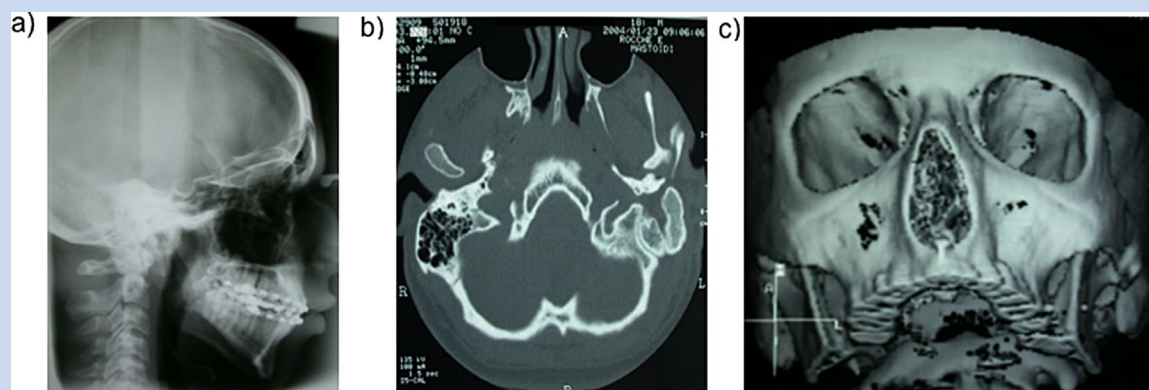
Radiography and CT scan images of the patient with OAVS features and the 3q29 microduplication. [a] Lateral cervical spine radiograph showing no alteration of cervical vertebrae; [b] Axial cranial CT scan at the level of auricles and external auditory canals showing the absence of the left external auditory meatus and dysgenesis of the inner ear system; [c] 3-D reconstruction of CT scan images showing the facial asymmetry.
